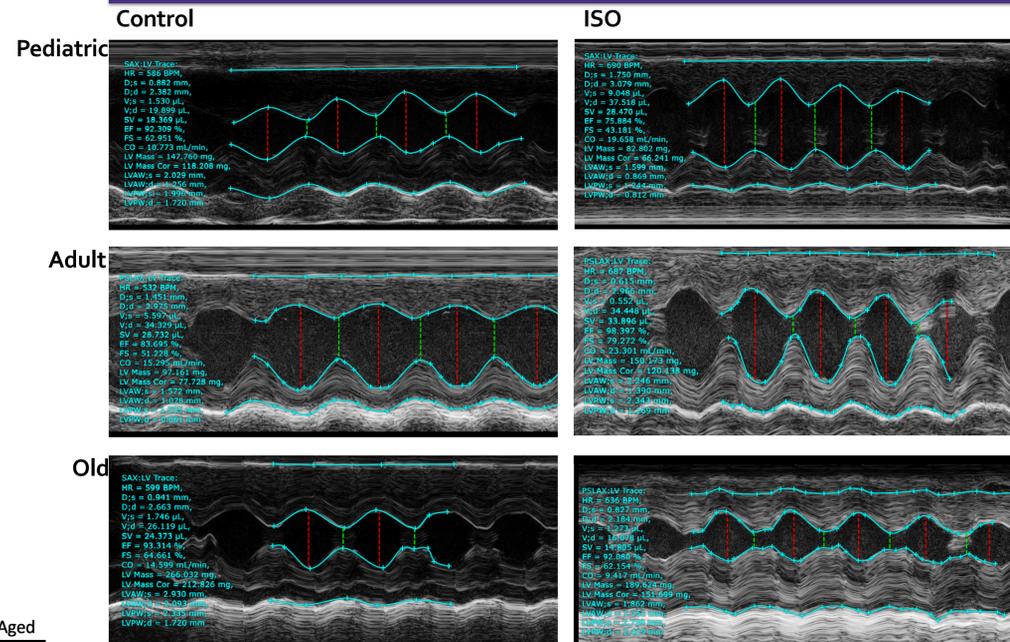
Echocardiography analysis of heart function viewed from the parasternal short axis in M mode
